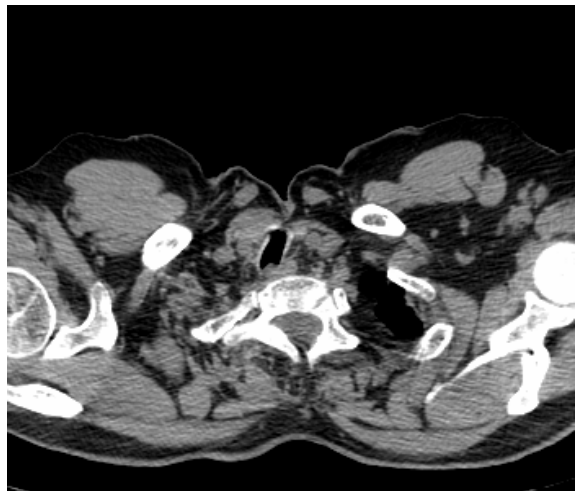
Chest CT, upper sections.
